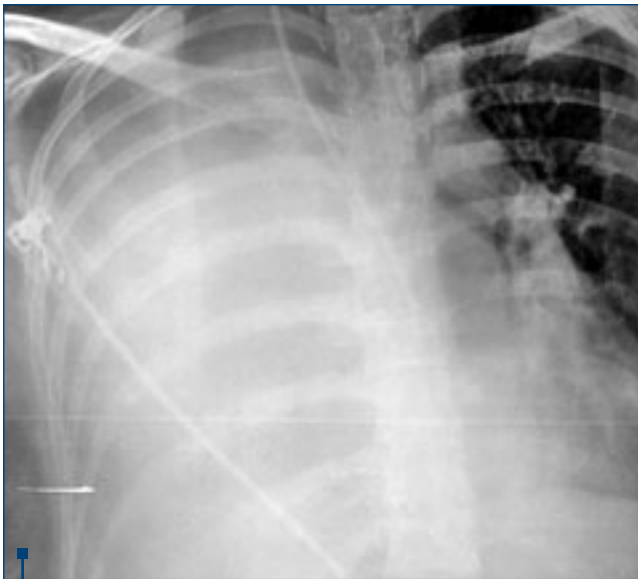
Chest X-ray at admission: opacity of the most of the right lung with contralateral mediastinal shift due to massive pleural effusion
